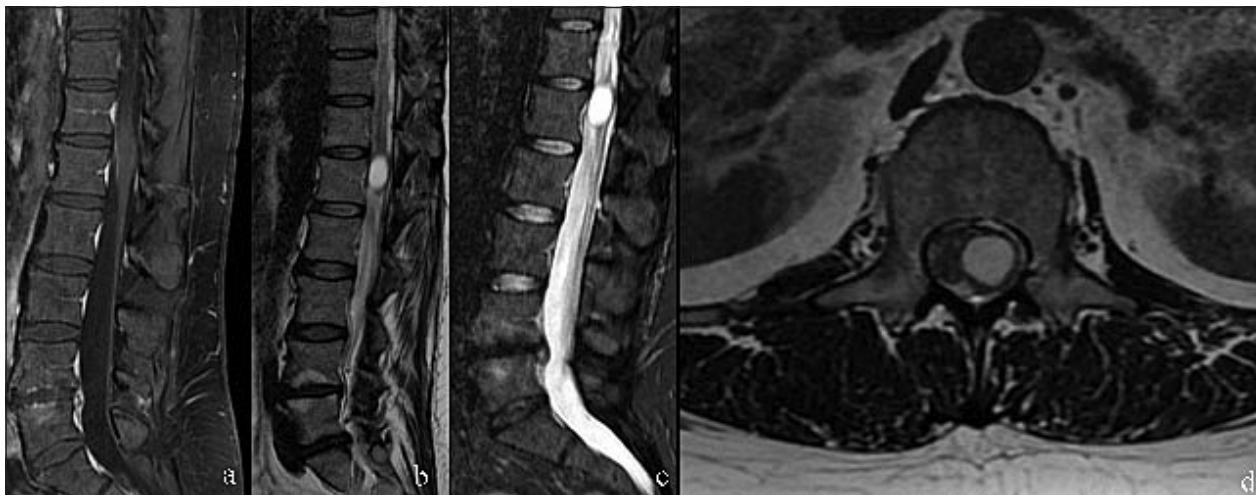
Lumbar spine MRI
